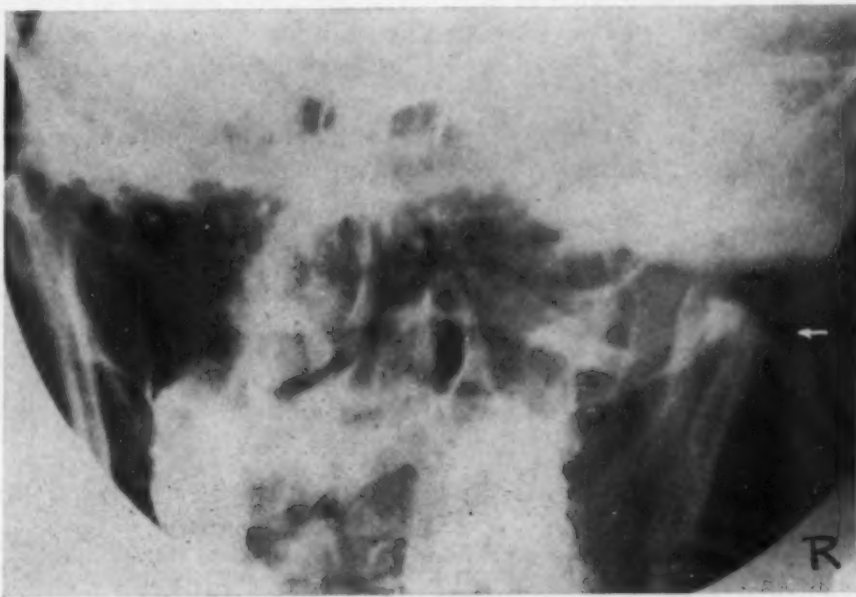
Postoperative x-ray after excision of condyle.
